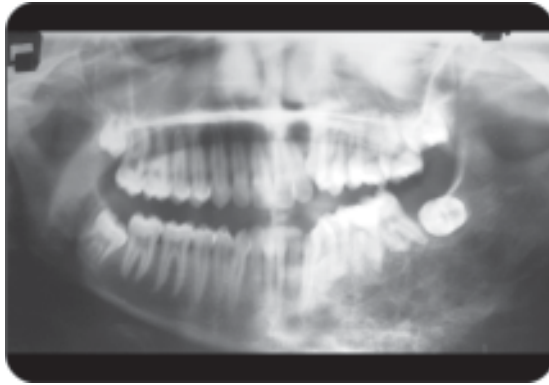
Radiographic view of central ossifying fibroma
